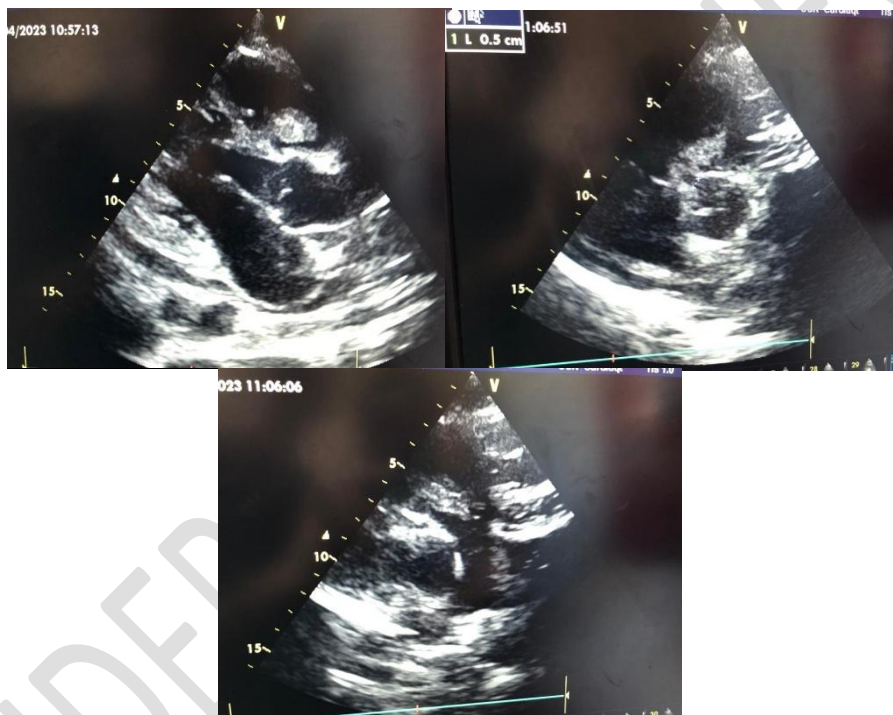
Transthoracic echocardiography showed an enormous vegetation measuring 35 x 33 mm inserted on the perimembranous ventricular septal defect, extending through the pulmonary infundibulum to the main pulmonary artery during systole.
